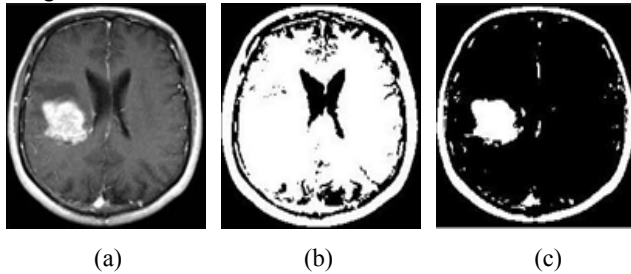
Output Image of HGG glioma tumor : (a) Brain MRI Image, (b) Otsu Thresholded Image, (c) Segmented Tumor.
